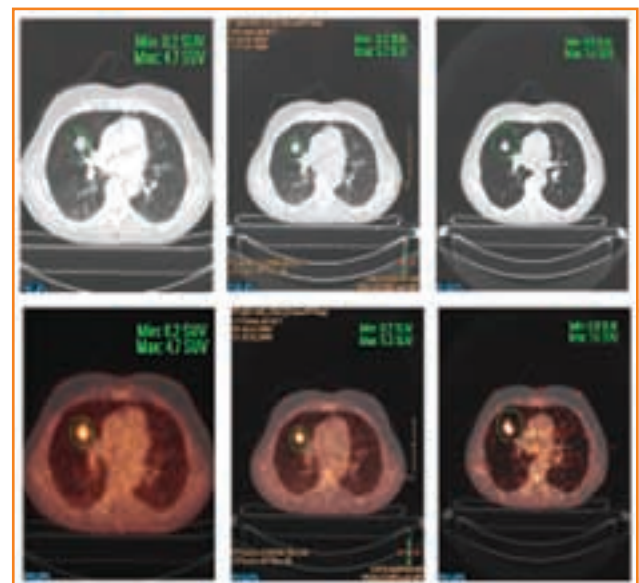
Reduction of motion artifacts using ultrafast PET acquisition and breath-hold techniques to image non-small-cell lung cancer lesion. Left: whole-body CT (top) and whole-body PET/CT (bottom). Center: 4D CT (top) and 4D PET/CT (bottom). Right: breath-hold CT (top) and breath-hold PET/CT (bottom). (Source: Czyborra-Brinkman J.¹³)
